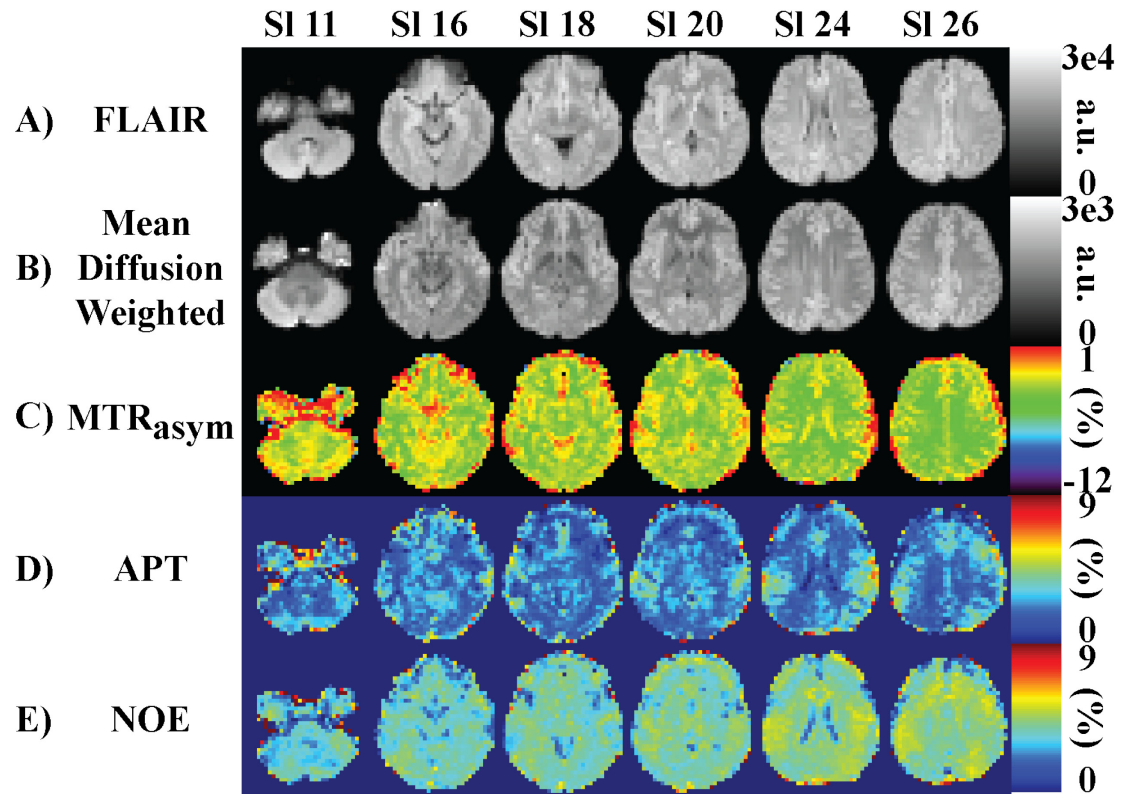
Data acquired on a healthy control subject. Select slices from the (A) FLAIR scan, (B) Mean Diffusion Weighted Image, (C)  $MTR_{asymmetry}(3.5 \text{ ppm})$  processed from the Steady State Pulsed CEST (pH-weighted), (D) APT processed from the Steady State Pulsed CEST scan, and (E) NOE processed from the Steady State Pulsed CEST scan.
